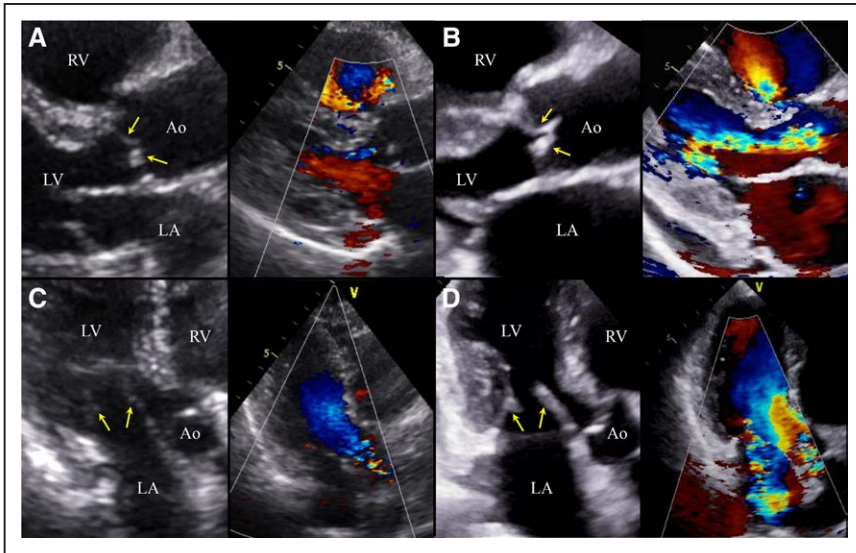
The time-course of changes in the echocardiograms of the left-sided heart valves. A and C, Aortic and mitral valves recorded 6 years earlier (arrows). B and D, Aortic and mitral valves recorded on admission (arrows). Left, The B-mode image; and right, the color Doppler image. Ao indicates aorta; LA, left atrium; LV, left ventricle; and RV, right ventricle.
